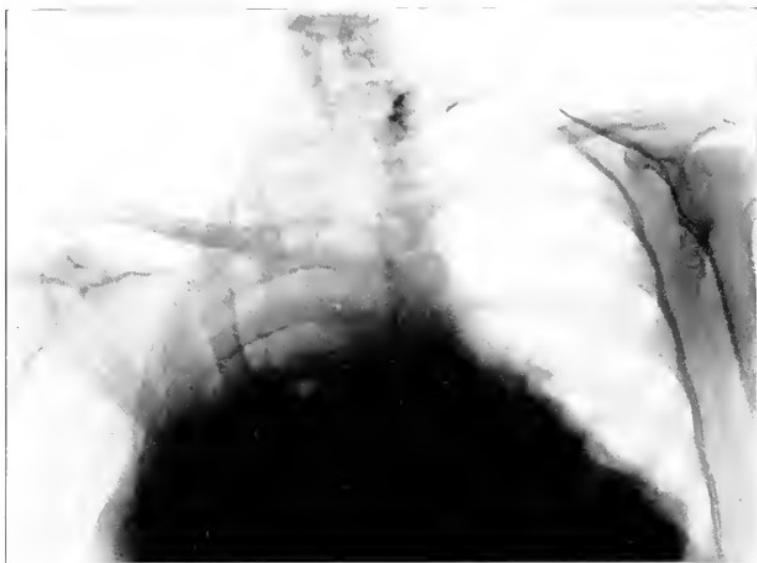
Roentgenogram (B. C.), taken before operation, showing marked curvature of the spine and displacement of the heart to the right.
